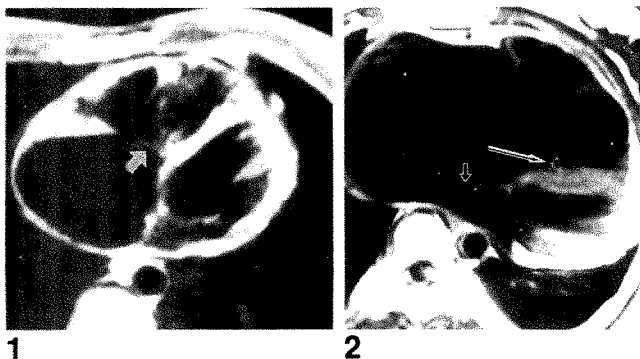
Transverse MR image of 30-year-old woman shows displaced septal leaflet (arrow) of tricuspid valve suggesting Ebstein anomaly.
